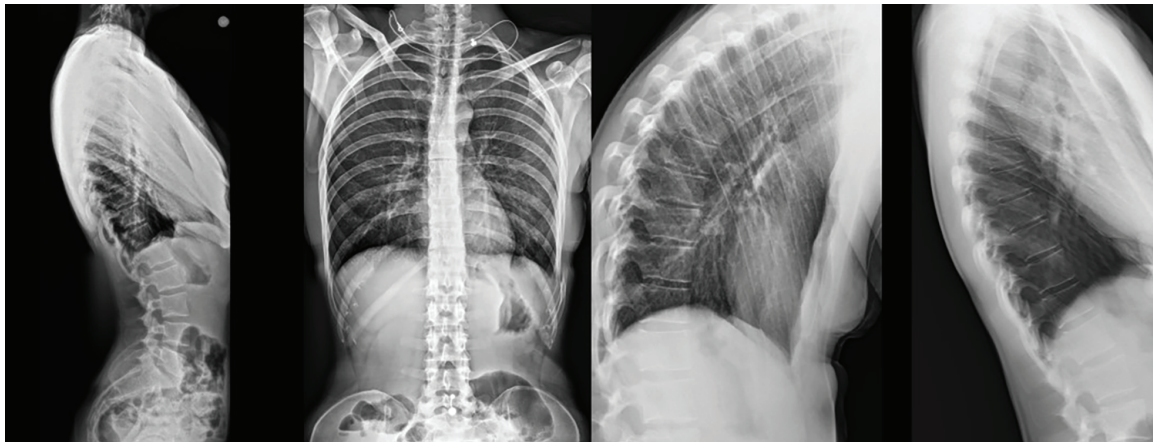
Pre-operative plain coronal and lateral radiographs of the thoracic spine demonstrating a 55-degree kyphotic angle from T4 to T10. Flexion and extension lateral views show that the hyperkyphosis does not change, indicating a rigid deformity. Additional findings include endplate irregularities and narrowed disc spaces, consistent with the diagnosis of Scheuermann's disease
